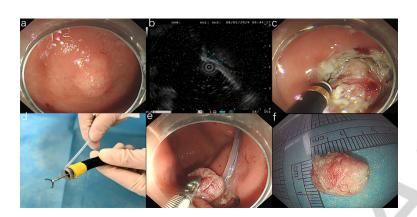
(a) Endoscopic view of the tumor in the stomach. (b) Endoscopic ultrasound indicated a hypoechoic lesion originated from the muscularis propria layer. (c) The tumor was dissected and exposed. (d) A over-the-scope snare was fixed to the transparent cap. (e) The tumor was removed by the snare combined with foreign body forceps. (f) The integral tumor.
